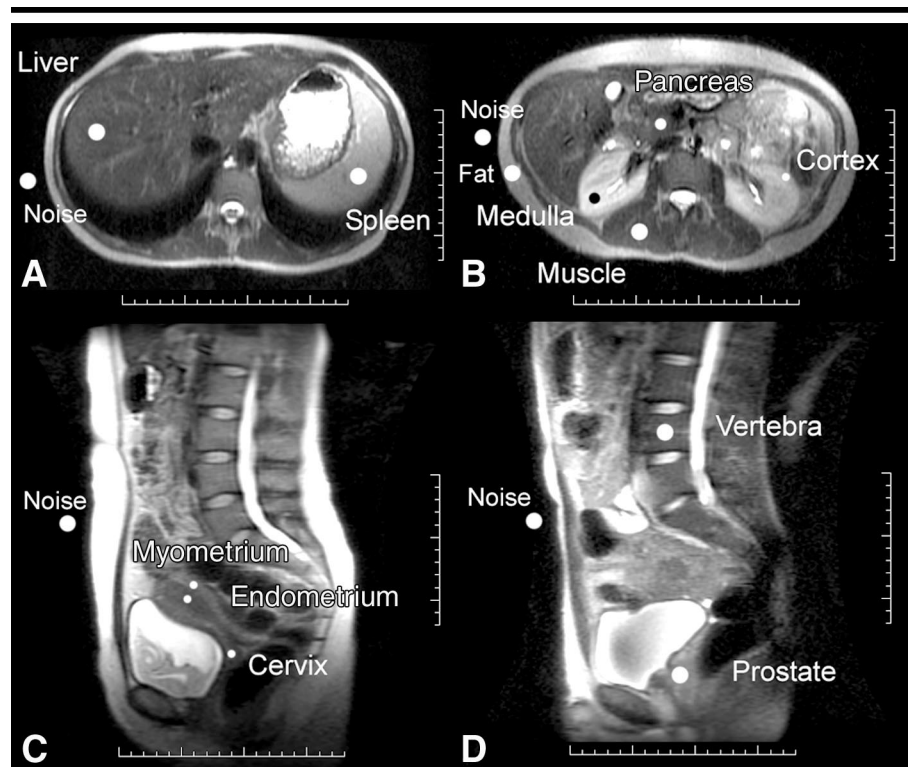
MR images obtained at 3.0 T with a half-Fourier acquisition single-shot fast SE sequence combined with inversion recovery (repetition time [TR], 5,000 msec; inversion time [TI], 150 msec; field of view, 360 × 252 mm; section thickness, 5 mm; acquisition matrix, 256 × 160; effective TE, 60 msec). Transverse sections through A, the liver and the spleen and B, the level of the kidney. Sagittal sections through C, the uterus, and D, the prostate and vertebra were used to generate the regions of interest (ROIs), which are indicated by white circles and labels. The scale is in centimeters.
